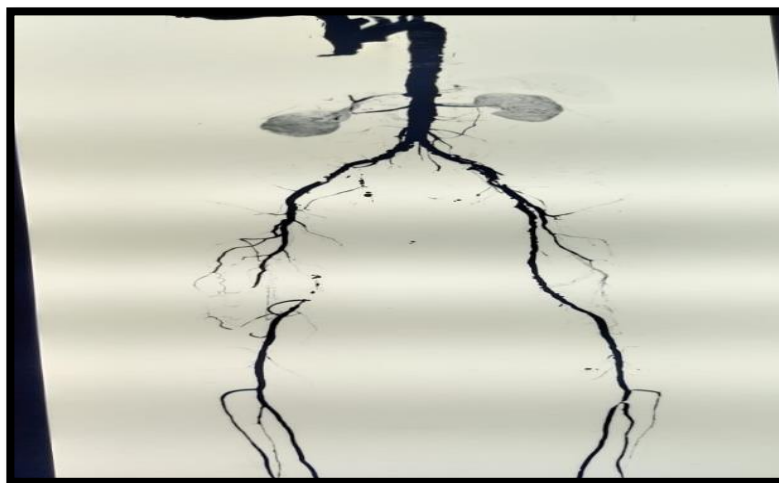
Preoperative computed tomography angiography
